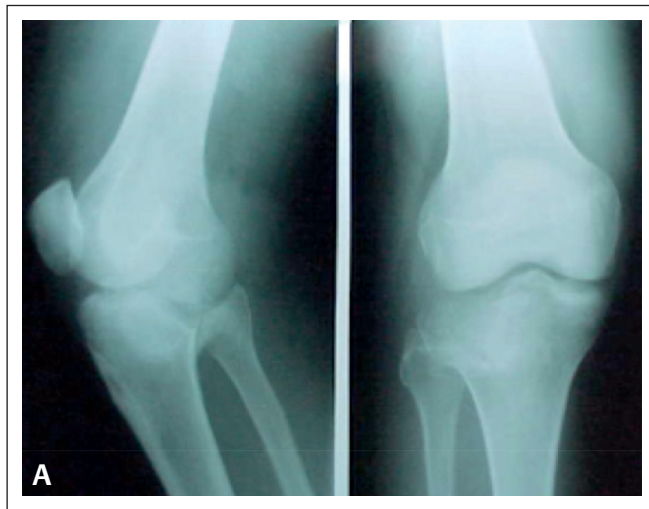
(A, B) X-rays showing Type II fracture, treated by open reduction, elevation, and buttress plate fixation. Postoperative X-rays showing excellent articular restoration.
